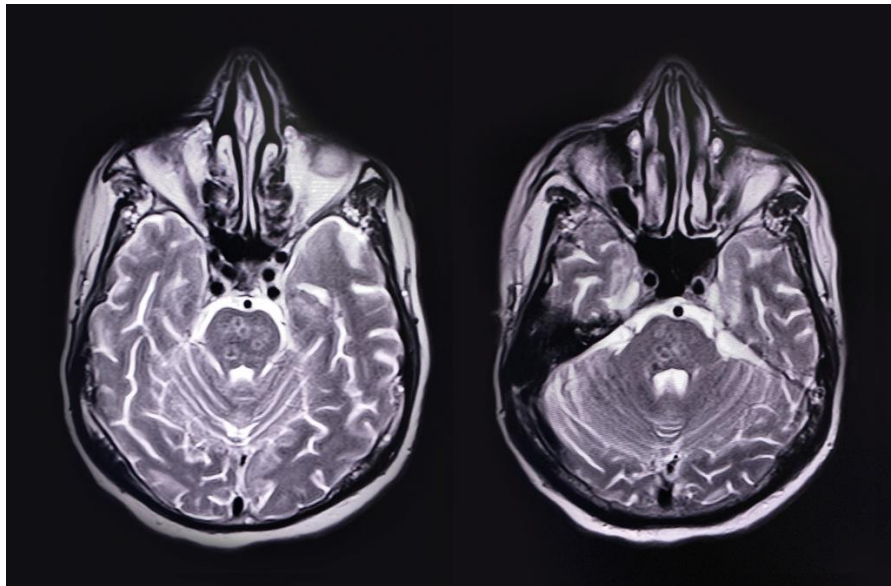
Magnetic resonance imaging (transverse T2-weighted MRI),with contrast revealed multifocal ring-enhancing lesions in medulla oblongata, pons and cerebellum.
